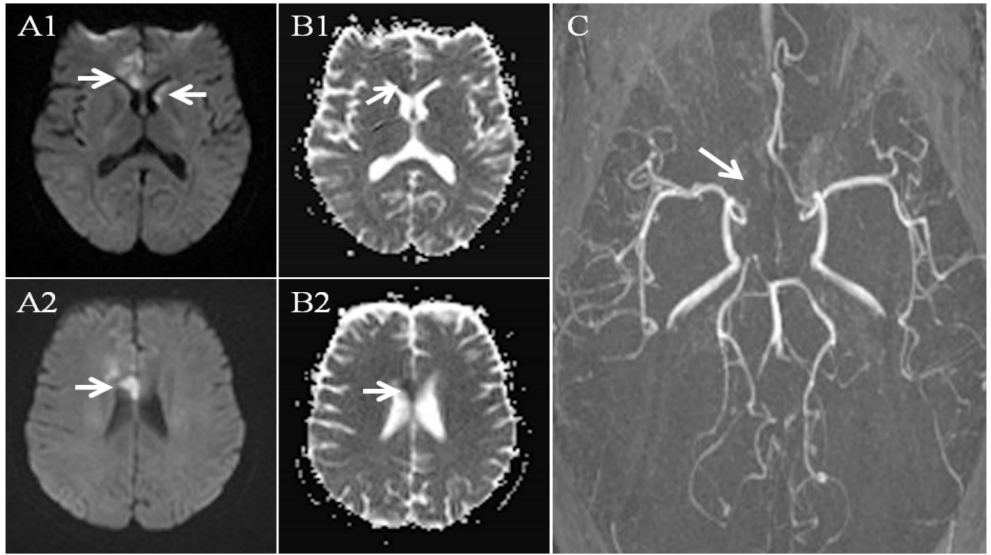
A 45-year-old female with TBM. (A1-A2) Axial diffusion-weighted imaging (DWI) and (B1-B2) apparent diffusion coefficient (ADC) showed multiple stroke lesions involving bilateral anterior circulation (arrow). (C) Magnetic resonance angiography (MRA) showed occlusion of right anterior cerebral artery (arrow).
